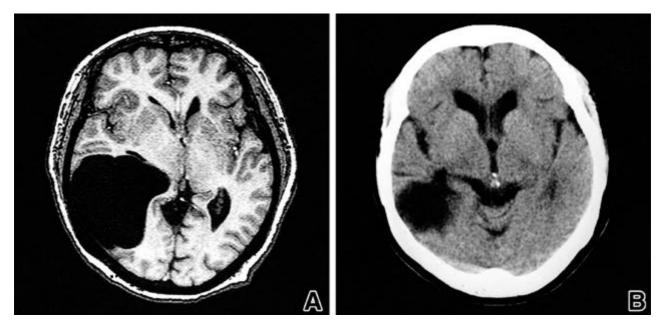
Radiologic findings in case 3. A) Axial T1-weighted magnetic resonance (MR) image revealing an arachnoid cyst in the middle cranial fossa with compression of lateral ventricle and midline shift. B) Axial computerized tomographic (CT) image obtained 18 months after surgery, demonstrating cyst reduction and disappearance of midline shift.
